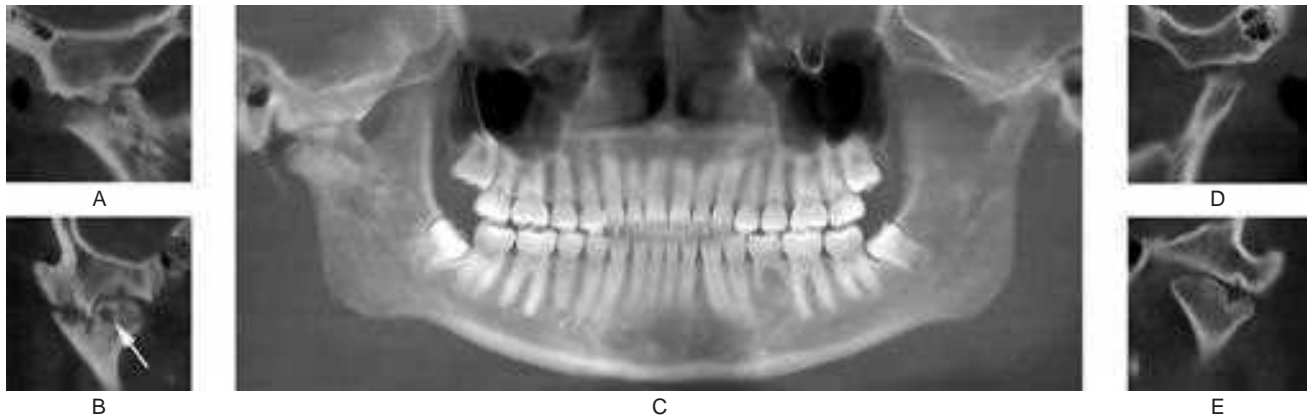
Cone beam computed tomography of a patient with bilateral involvement with rheumatoid arthritis.
